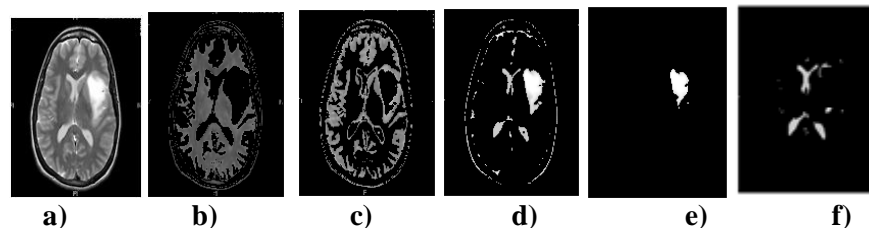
extraction of normal and abnormal tissue from MRI brain images.
